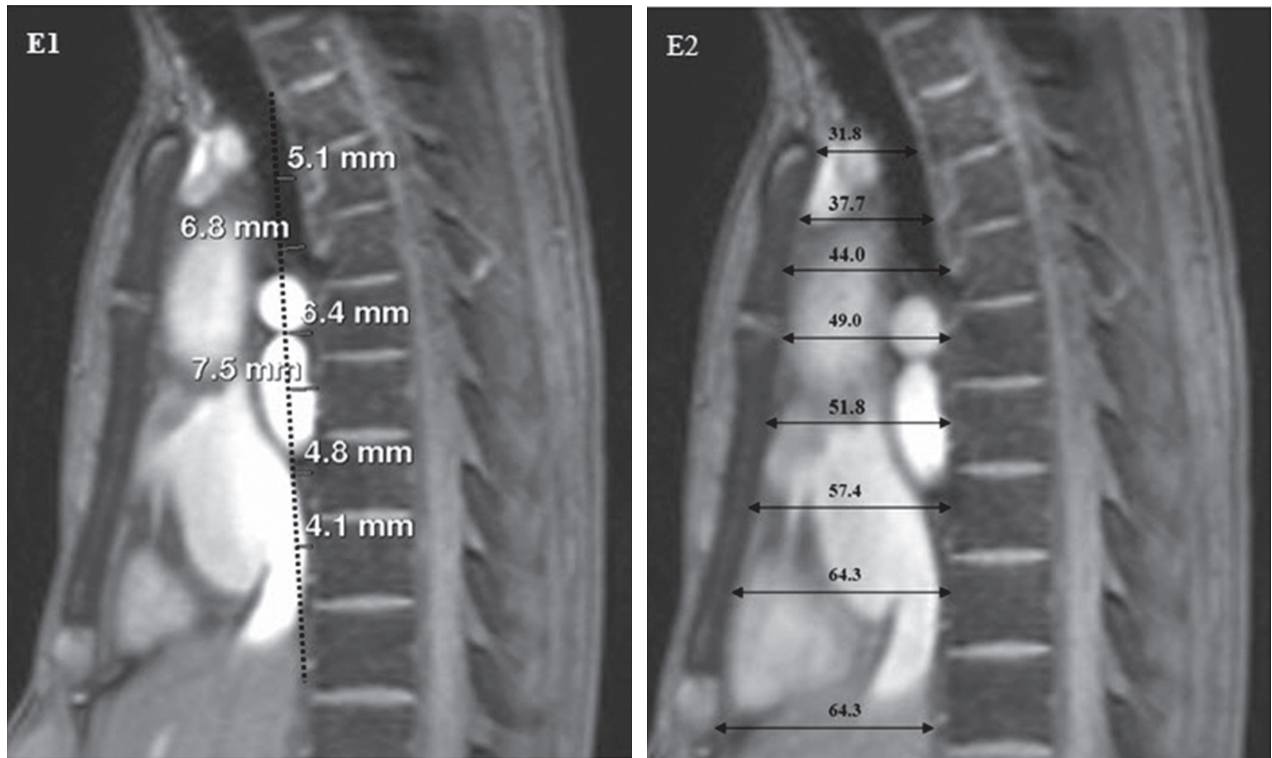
E2: Shows the short-cut method to diagnose SBS using MRI by measuring the distance (D2) between the anterior surface of the thoracic spine to the vertical line that connects between the posterior surface of the superior of the thoracic spine (that is opposite to the suprasternal notch and the posterior surface of the thoracic spine that is opposite to the Xyphoid) in every image slice on the sagittal view of the thoracic spine (E1). If the distance is less than 1.2 cm, SBS is diagnosed. The measurement of the A-P dimension of the thoracic cage on the sagittal view (by measuring the distance (D2) between the anterior surface of all the thoracic spine located within the length of the angle of Louis to the xyphoid to the posterior surface of sternum on the MRI image) on the sagittal view of the thoracic spine (E2) is necessary to make sure that the maximum distance value is measured. If the maximum value of the A-P dimension is less than 11 cm in female and 12 cm in male then SBS is diagnosed. The patient has D1 = 7.5 mm and D2 = 6.43 cm hence SBS diagnosis is confirmed.
